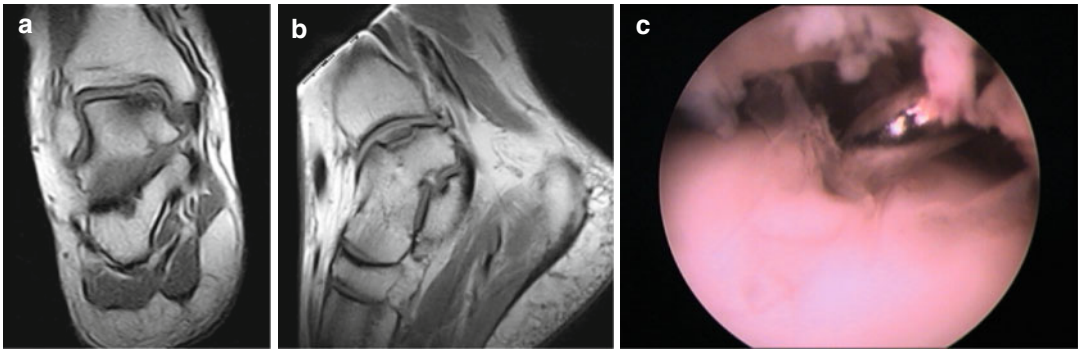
(a–c) Osteochondritis dissecans – diagnosis in MRI and in arthroscopy
